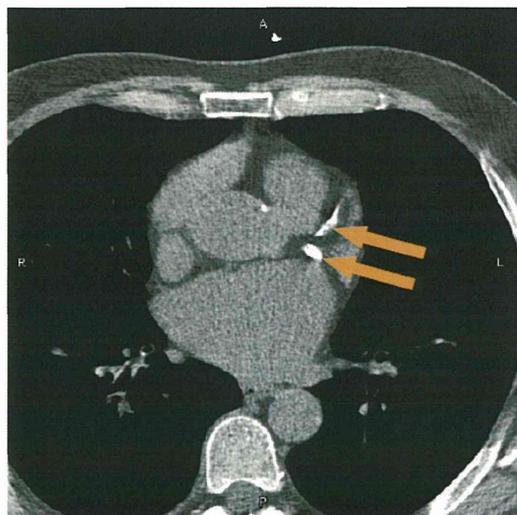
Arrows indicate extensive calcification of the left coronary artery on the cardiac computer tomography (CT).
